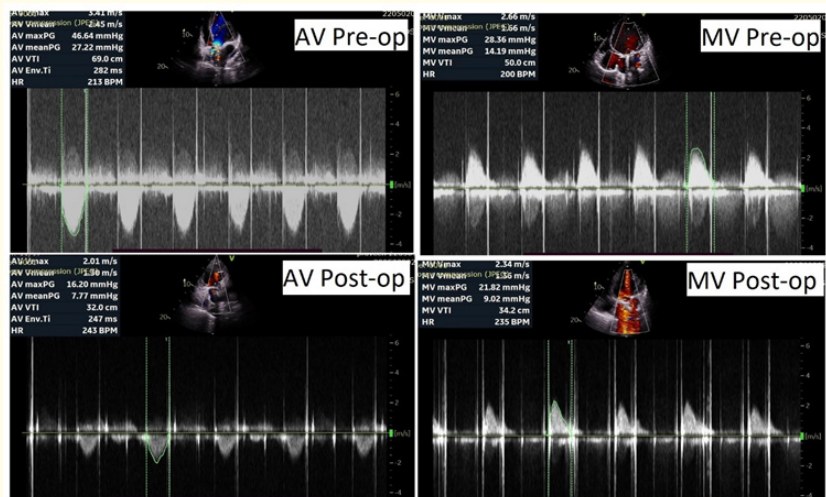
Transthoracic echo images comparing prosthetic valve gradients of initial and re-do double valve replacement. AV: Aortic valve, MV: Mitral valve.
